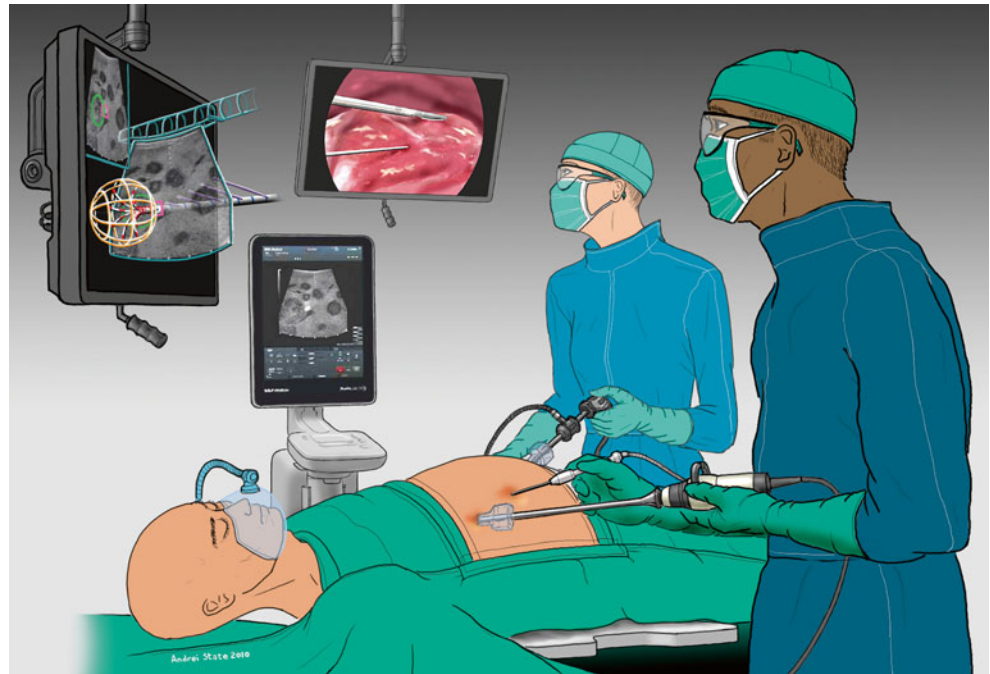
Intraoperative photo of a laparoscopic liver tumor ablation using the EMTS. Note side-by-side monitors with stereoscopic 3-D ultrasound navigation image and laparoscopic image. Some of the surgeons are wearing lightweight passive 3-D stereo glasses
